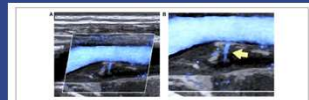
A longitudinal B-mode ultrasound image of a carotid artery. A green box highlights a region of interest.
